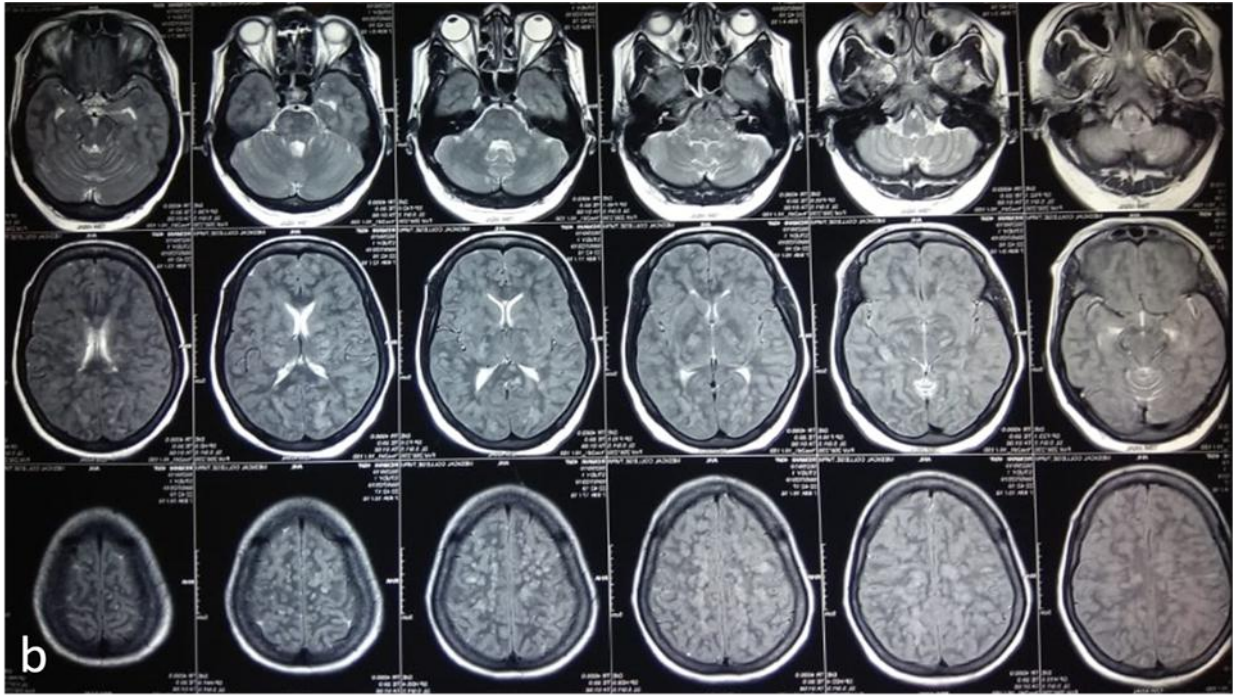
a & b T2/FLAIR hyperintensities involving subcortical and deep white matter sparing basal ganglia and thalamus.
